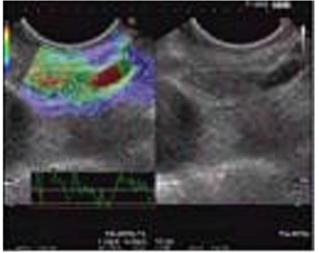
Endosonography showing lymph node in the right half of the figure and elastography showing benign nature of lymph node in the left half of the figure.
